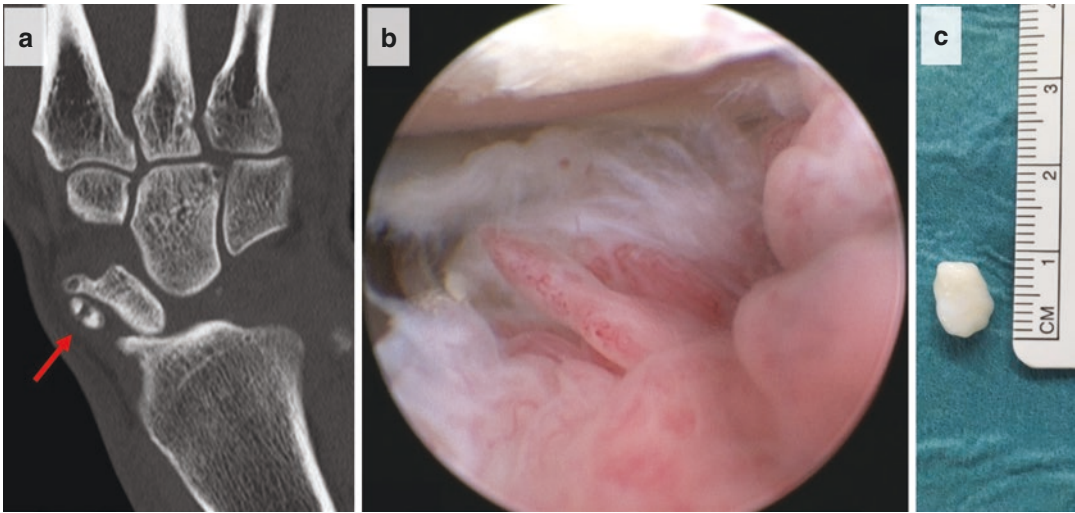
A 43-year-old male climbing athlete with ulnar-sided wrist pain. CT scan shows an intra-articular body in the wrist joint (a, arrow). Arthroscopy of the wrist shows
